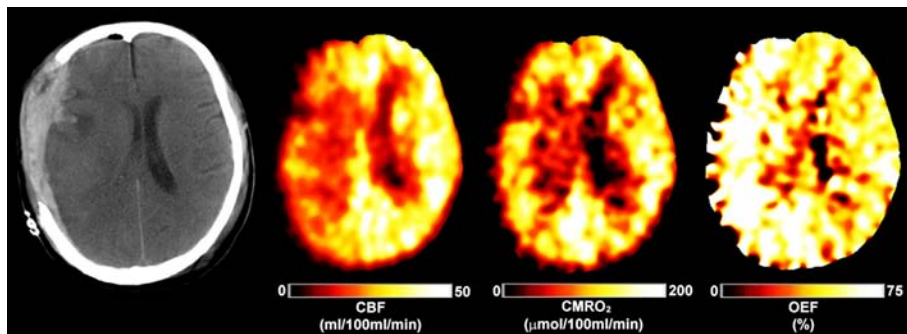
Positron emission tomography images following early head injury. X-ray computed tomography, cerebral blood flow (CBF), cerebral metabolism (CMRO₂) and oxygen extraction fraction (OEF) images obtained from a 42 year old female 16 hours post injury following evacuation of a subdural haematoma. Note the marked reductions in CBF, increases in OEF and relatively maintained CMRO₂, which are suggestive of ischaemia. These physiological derangements extend beyond the cortical tissue immediately underlying the evacuated subdural haematoma.
